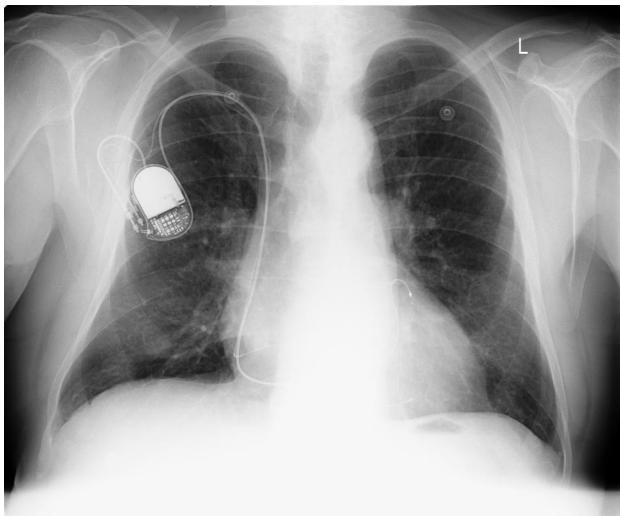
Anterior-posterior chest X-rays taken at implantation (left) and one week after implantation (right). Note the reduction of Kerley lines one week after implantation.
